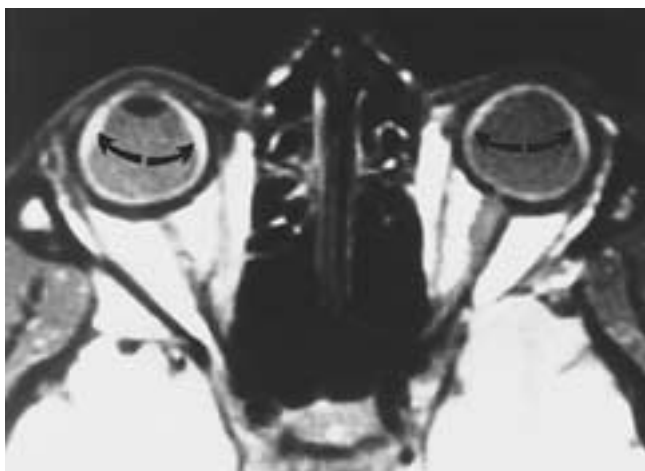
Bilateral choroidal effusion. Axial PW MR image shows bilateral ring-shaped areas of increased signal intensity (arrows). This MR appearance may be difficult to differentiate from that of retinal detachment. (From Mafee MF et al. Choroidal hematoma and effusion: evaluation with MRI. *Radiology* 1988;168:781–786.)
